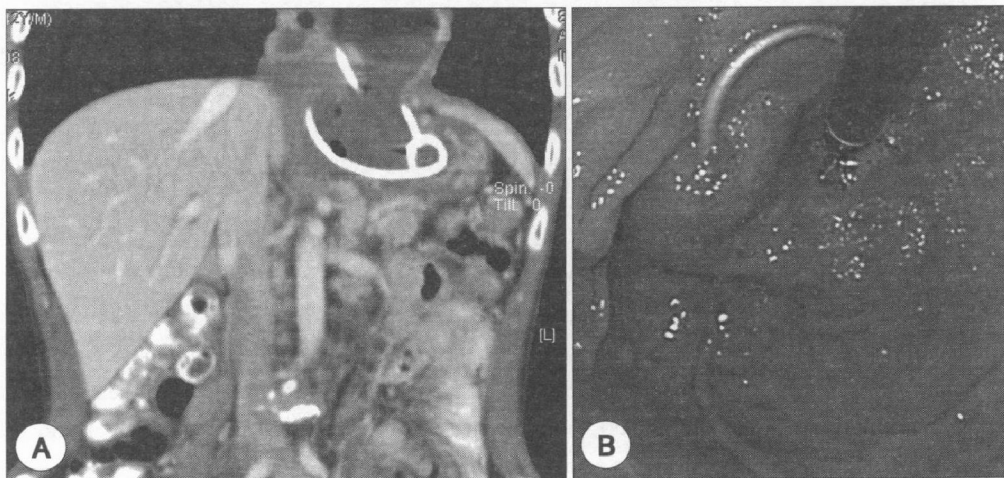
A : Abdominal CT scan shows inserted tube in cystic lesion. B : Endoscopic view shows inserted transmural nasopancreatic drainage tube in the gastric cardia.
